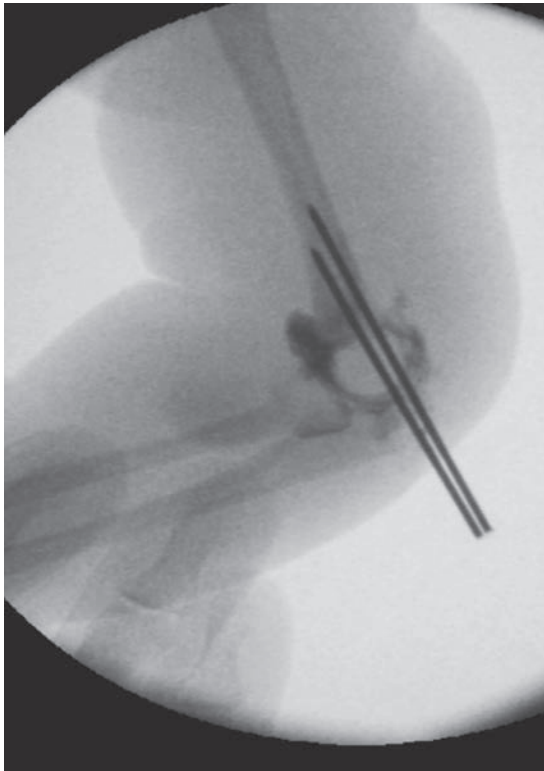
MRI (A) demonstrating transphyseal separation of the distal humerus and arthrogram (B, C) demonstrating realignment after pin fixation.
